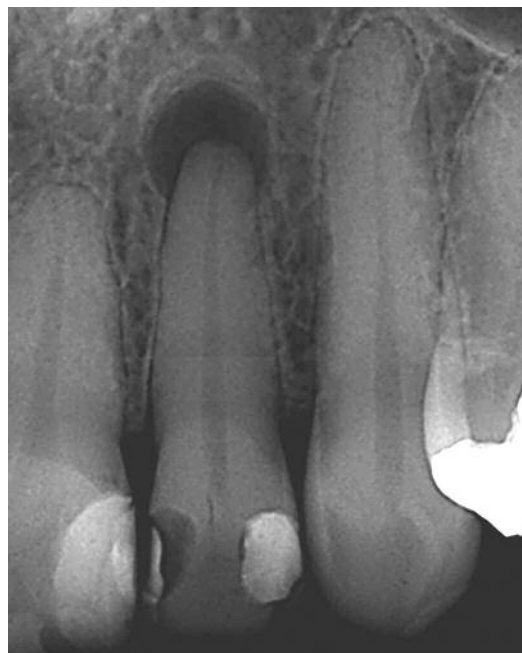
Case one: radiographic examination revealed a large periapical area the around apex of the root and confirmed that the tooth was non-vital.
